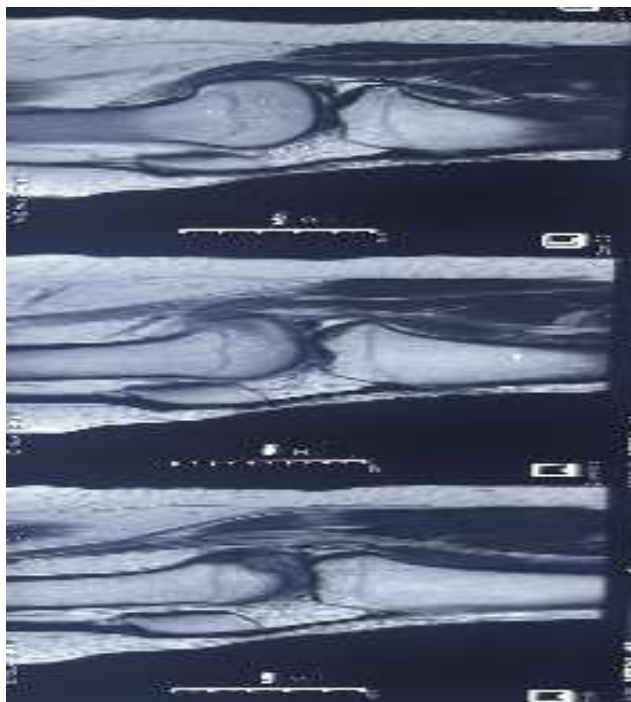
Preoperative MRI of the right knee showing lateral meniscus tear
